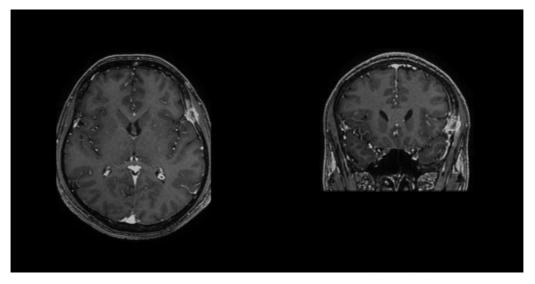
Contrast-enhanced brain magnetic resonance imaging. Axial and coronal views are shown, in which a lesion with peripheral enhancement is seen, compromising the dura of the left temporal convexity as well as the temporalis muscle and the squamous portion of the temporal bone.
